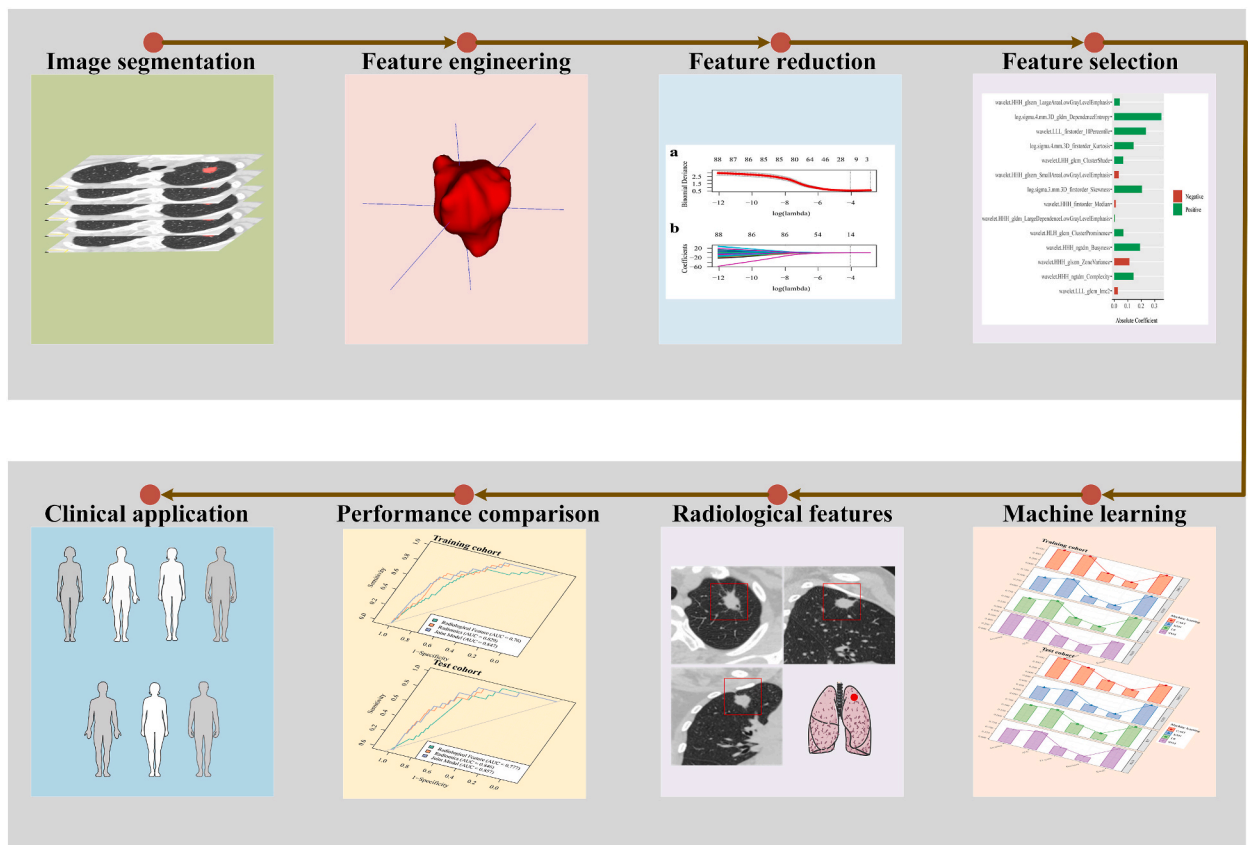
Framework outlining the essential steps of computed tomography image acquisition, tumor segmentation, feature extraction, dimensionality reduction, and subsequent machine-learning analysis that is crucial for the development of a radiomic model.
